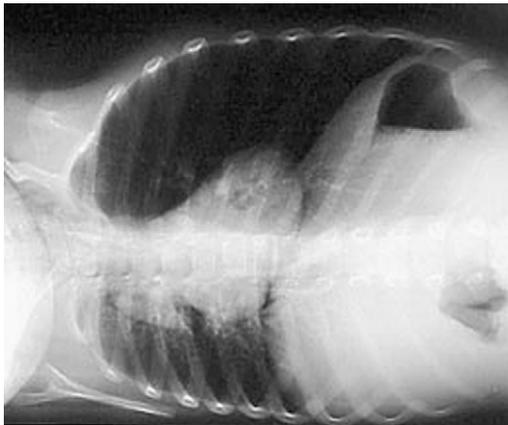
Same patient as in Fig. 2; normal right lateral decubitus chest radiograph. Note how the right lung compresses normally due to the effects of gravity.
